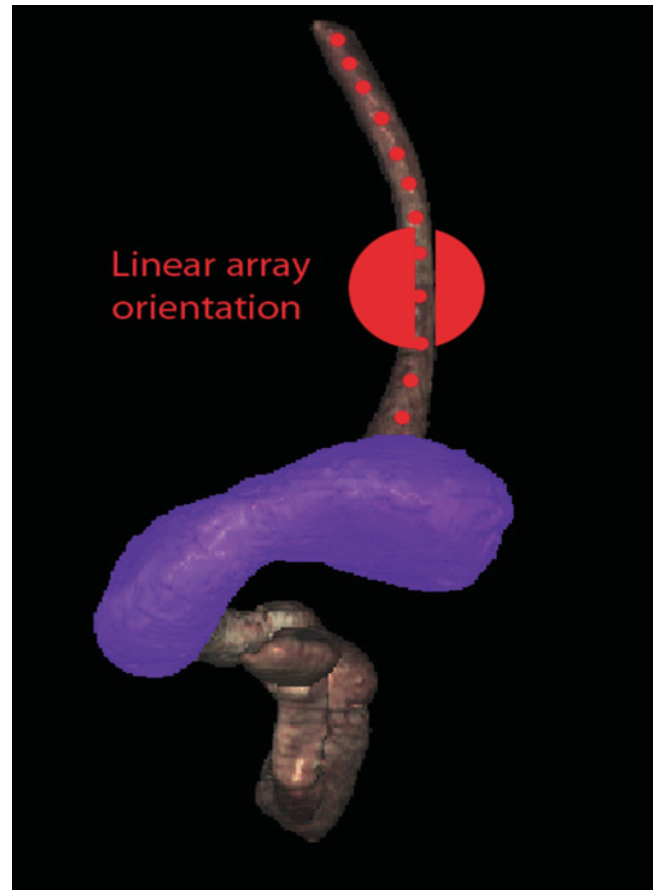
Visible Human Model of esophagus, stomach, and duodenum. The red circle shows a plane parallel to the axis and is similar to a plane developed during linear array endosonography.
